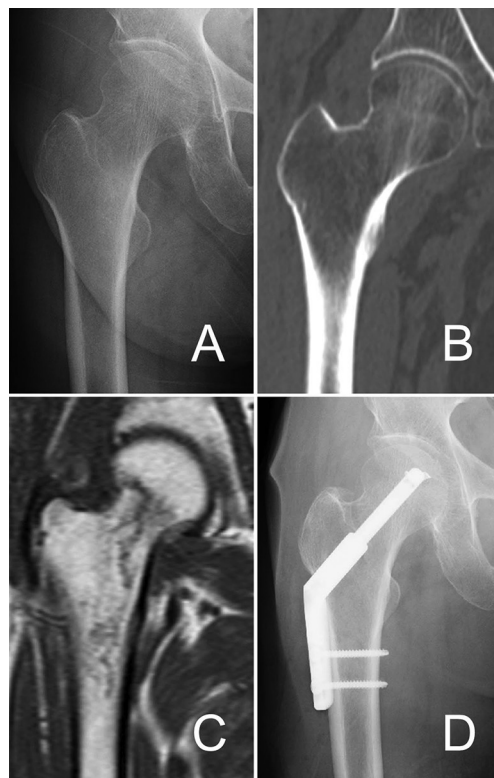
(A) A radiograph of the right hip revealed no evidence of fracture. (B) A CT of the right hip revealed no evidence of fracture. (C) MRI (T1-weighted coronal imaging) revealed oedema of the right femoral neck. (D) Patient was treated with osteosynthesis.
